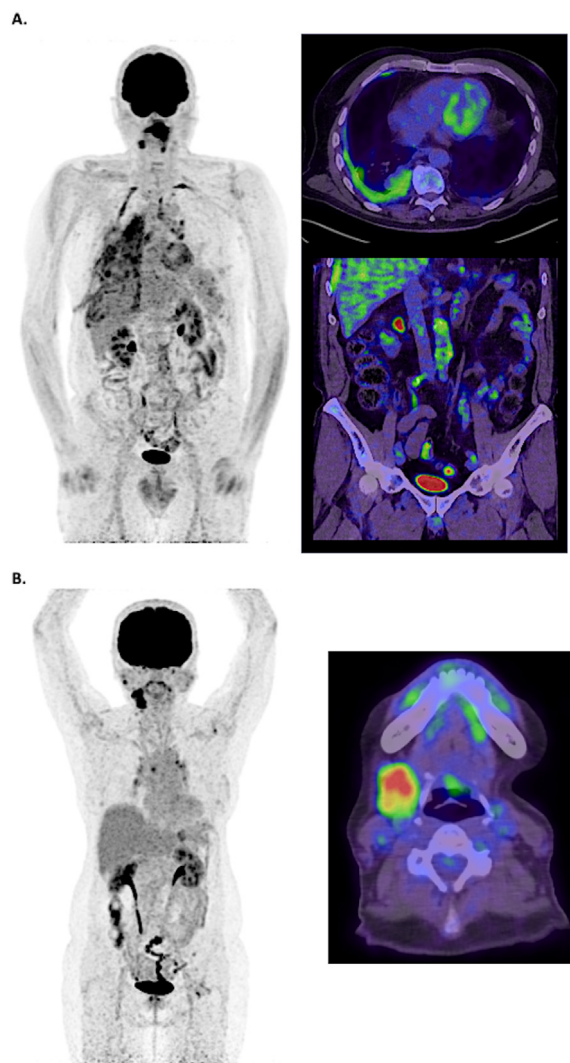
IgG4-RD: a wide variety of patterns on FDG PET. The most frequently reported sites are lacrimal and salivary glands, chest (parenchyma, pleura and mediastinum), pancreas and biliary tree, kidney, and retroperitoneum. (A) Pleural effusion and retroperitoneal fibrosis; (B) Right submandibular gland involvement.
